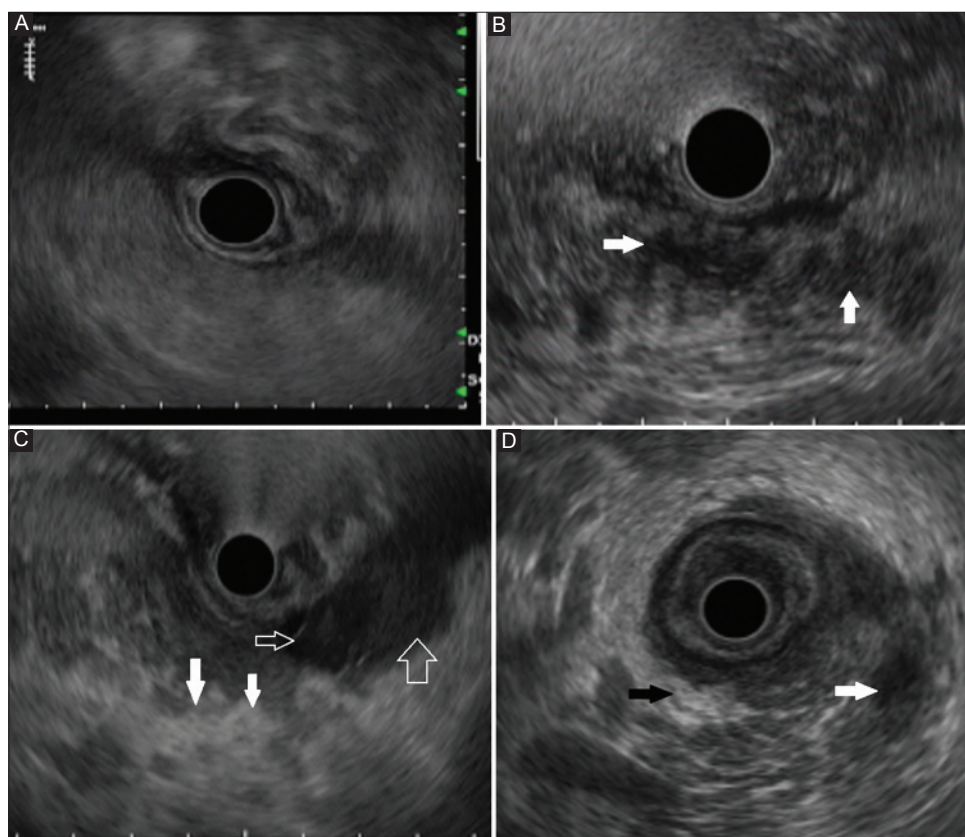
Endoscopic ultrasound in (A) acute interstitial pancreatitis: Diffusely increased echogenicity. (B) Necrotizing pancreatitis: Multiple hypoechoic areas (arrows). (C) Necrotizing pancreatitis: Multiple hyperechoic areas (bold arrows). Peripancreatic echogenicity suggestive of extrapancreatic necrosis also seen (open arrows). (D) Necrotizing pancreatitis: Mixed hyperechoic (black arrows) and hypoechoic areas (white arrows)
